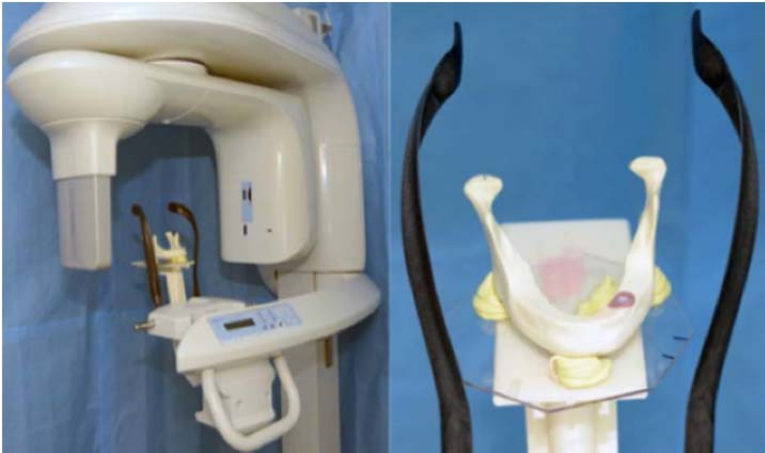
A limited FOV CBCT was used to capture scans of extracted teeth positioned in the left premolar region of an artificial mandible.
